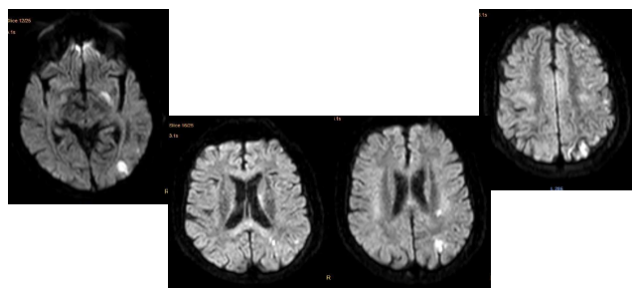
MRI at initial discharge revealing patchy infarcts in left MCA artery
